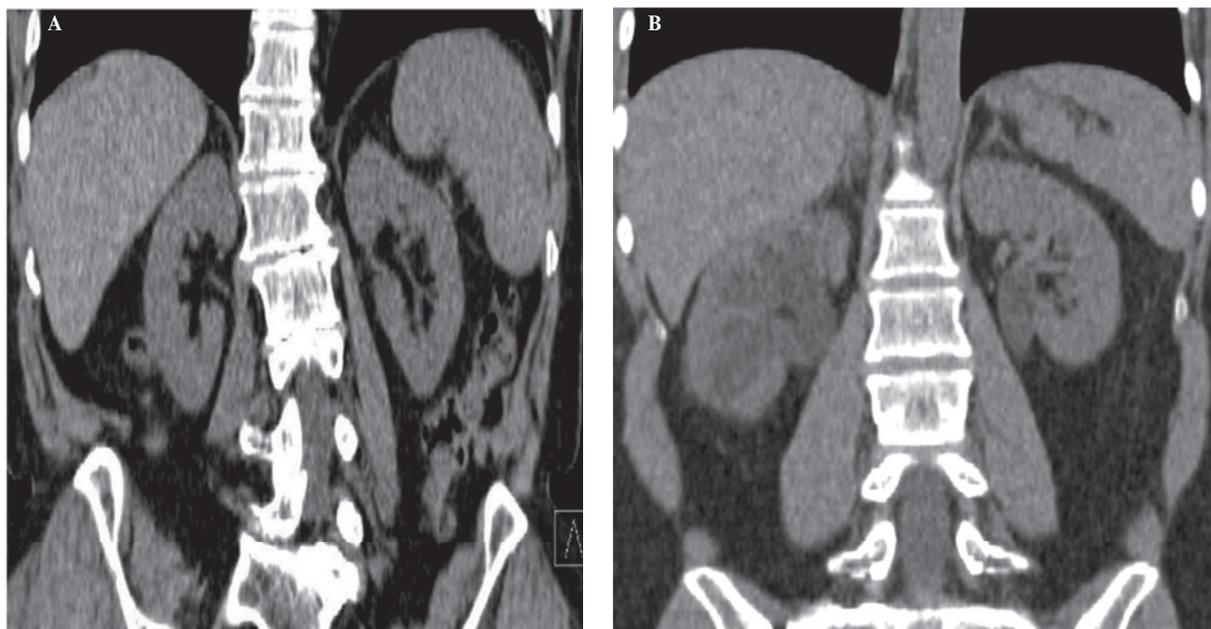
Non-contrast-enhanced computed tomography of the kidneys.
